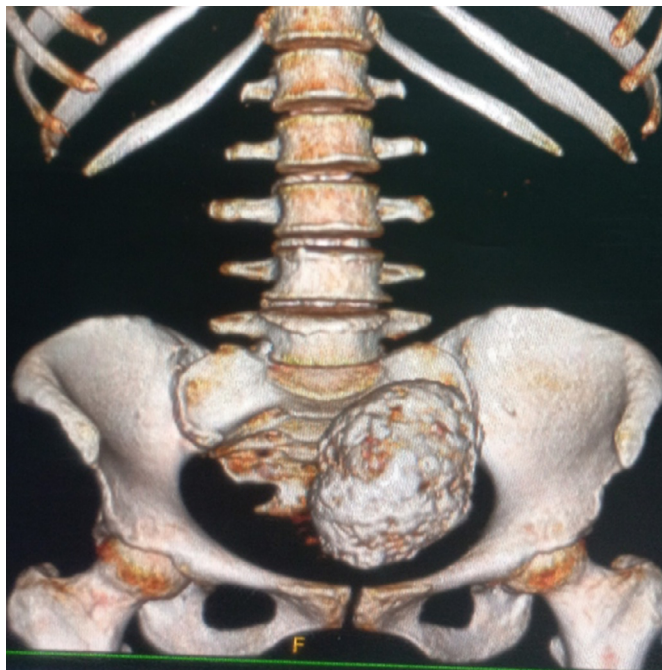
Abdominal CT in 3D reconstruction. A 3D CT reconstruction, anteroposterior view shows a left pelvic calcified mass corresponding to the lithopedion of 11 cm.
